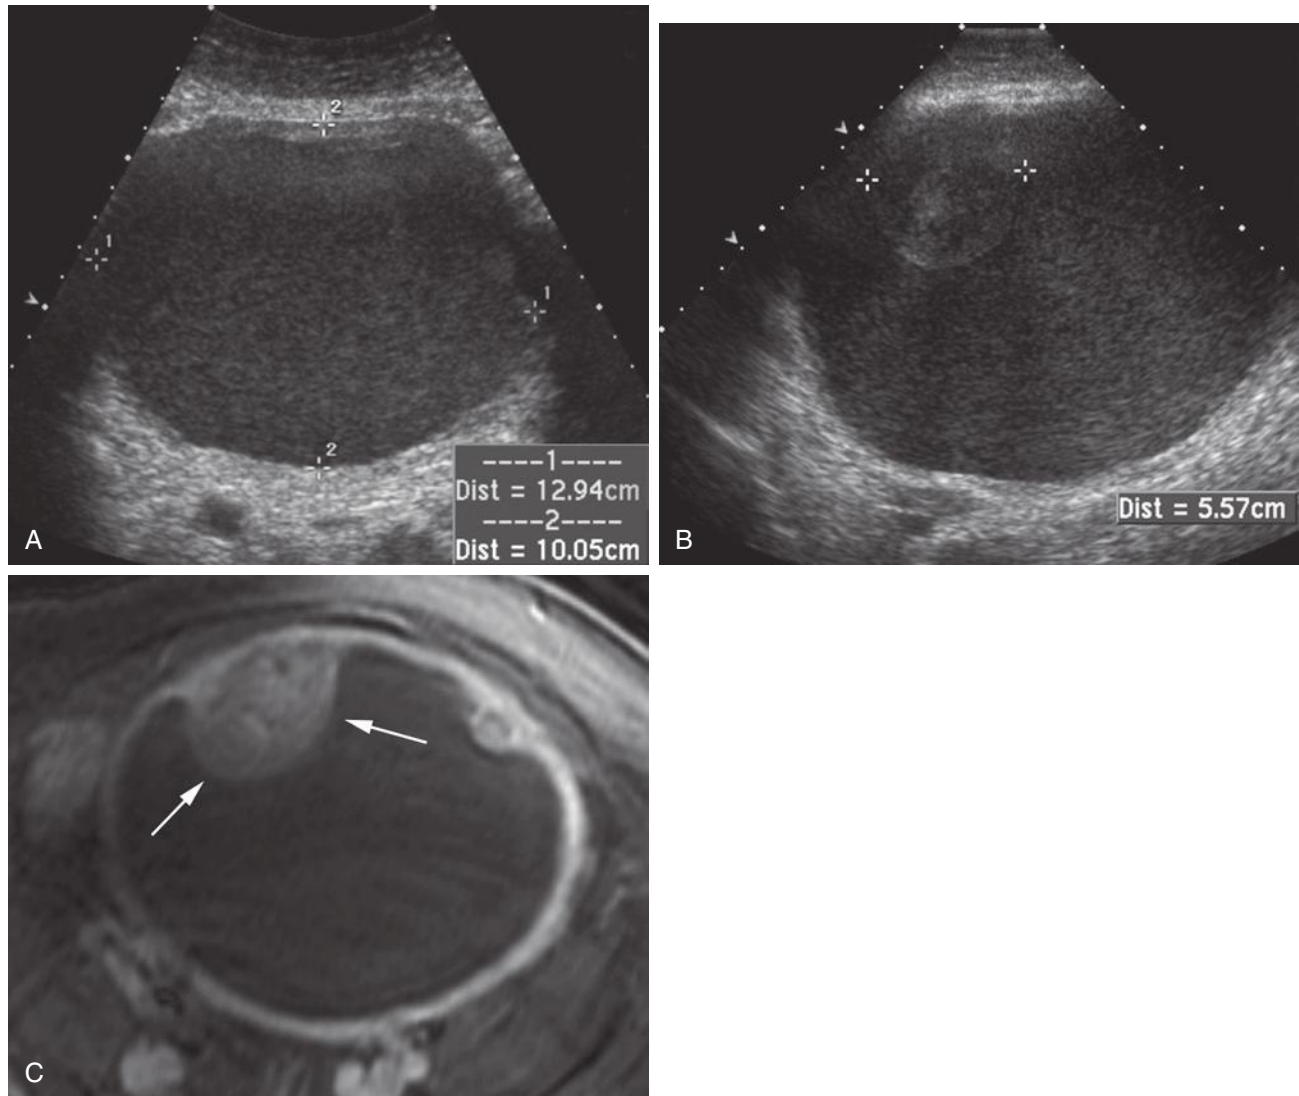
Leiomyosarcoma. Postmenopausal woman with history of stable degenerating leiomyoma. A, Transabdominal sonogram demonstrating cystic degeneration of a leiomyoma (*calipers*). Note low level homogeneous internal echoes and increased through transmission. B, Transabdominal sonogram 2 years later demonstrates a new mural nodule (*calipers*). C, Axial T1-weighted with fat saturation postcontrast magnetic resonance image demonstrates enhancement of the mural nodule (*arrows*). Surgical removal and pathologic examination revealed low-grade sarcoma without myometrial invasion.
